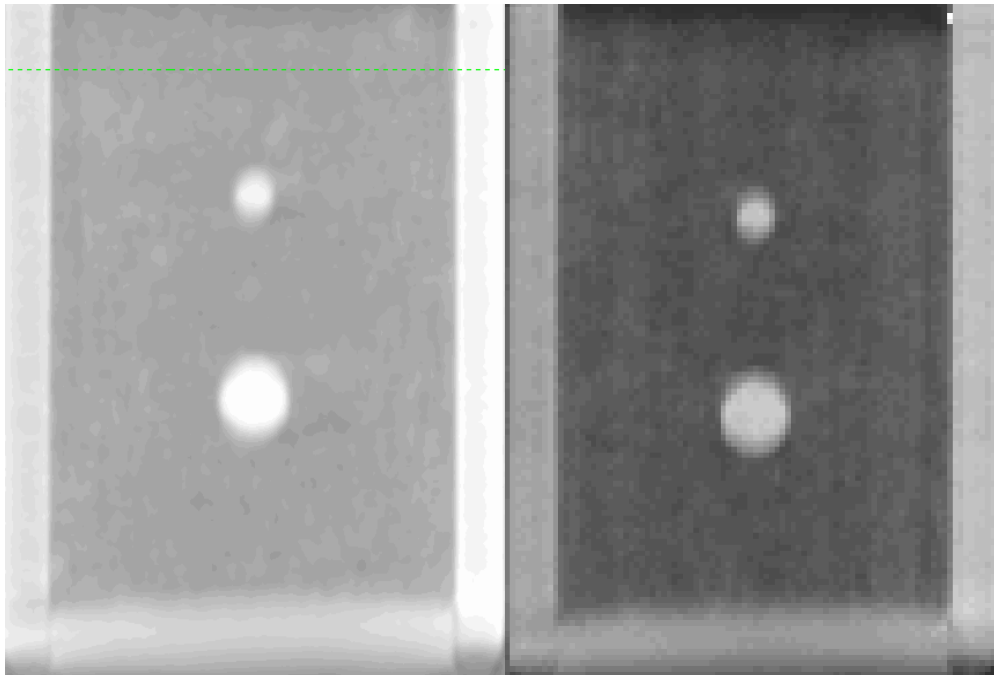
Comparison of CBCT (left) and 4DCBCT_{average} images (right)
